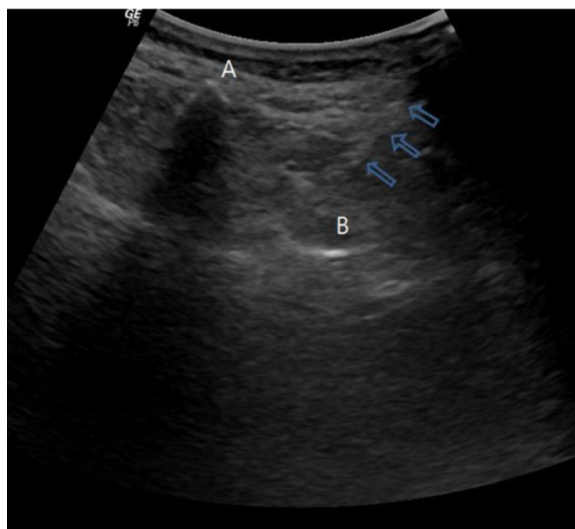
Transverse ultrasound image of dorsal root ganglion radiofrequency ablation at the L2 level
